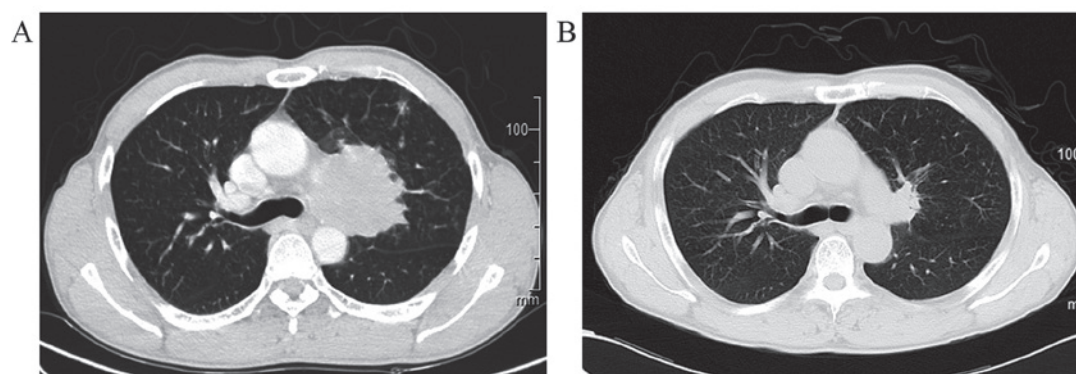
(A) Computed tomography (CT) image of the chest (axial view) showing a soft tissue mass measuring 7.2x2.4 cm in the left hilum; (B) Follow-up CT scan after 4 cycles of chemotherapy showing partial regression (PR), with the mass measuring 2.0x2.0 cm.
